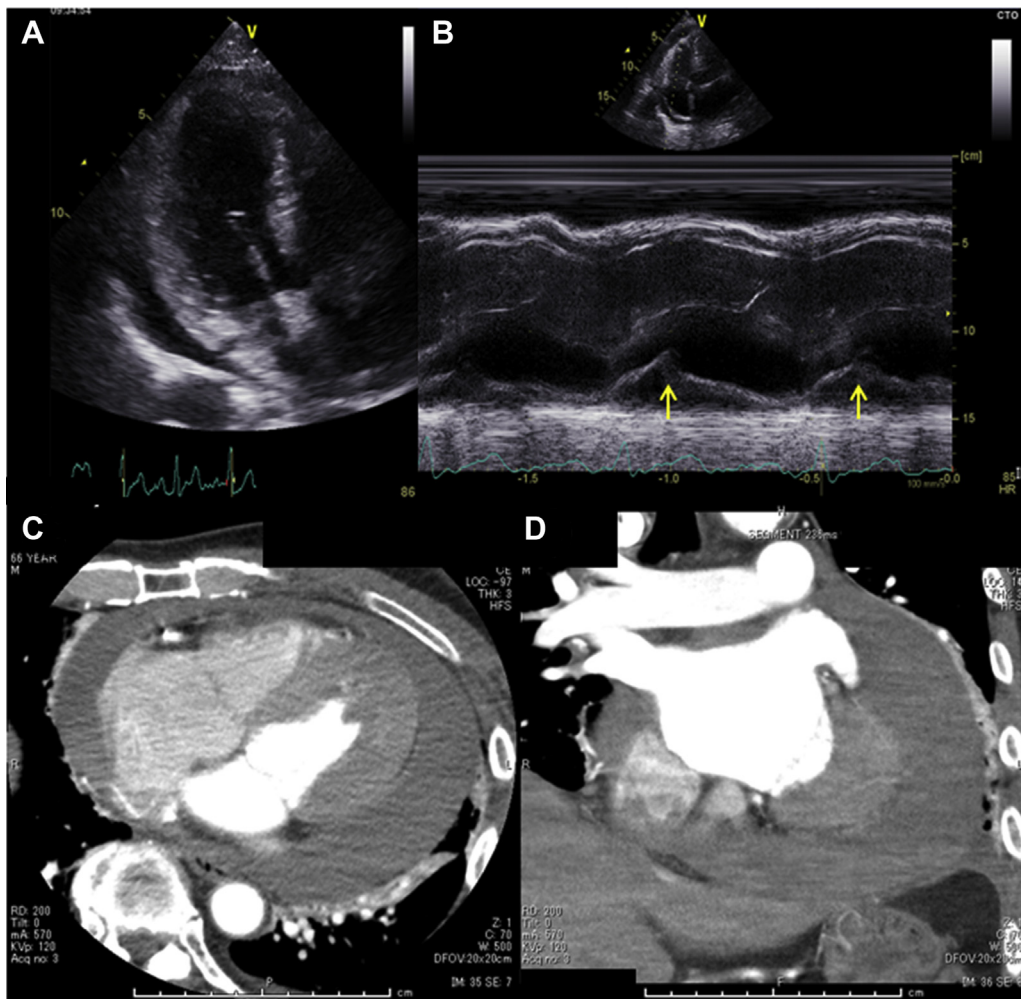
A: The apical 3-chamber view of transthoracic echocardiography (TTE) at end-diastole showing pericardial effusion of maximum 17 mm at the posterior side of the left ventricle. B: The M-mode TTE assessment at apical 4-chamber view showing collapse of right atrium (arrows). C, D: The axial (C) and coronal (D) views of cardiac computed tomography scan showing pericardial effusion of 25–30 mm around the left atrium and ventricle.
